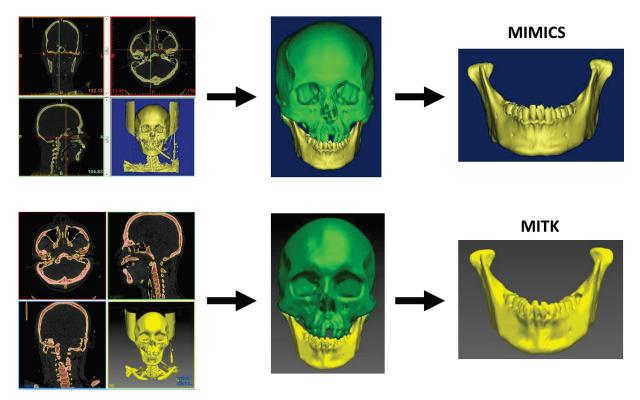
SEGMENTATION OF THE HARD TISSUES AND MANDIBLE USING MIMICS AND MITK SOFTWARE. 1(A): CT DATA IN DICOM FORMAT VISUALISED IN MIMICS AND MITK SOFTWARE 1(B): EMBEDDED TEETH BETWEEN MAXILLA AND MANDIBLE 1(C): THE FINAL 3D MODEL AFTER SEPARATION OF MANDIBLE FROM THE SKULL
